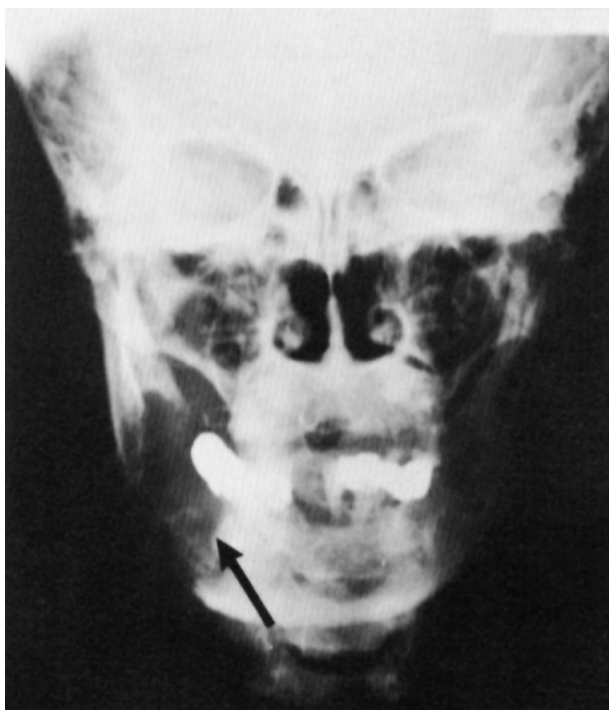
Radiographic appearance showing the tumor (arrow) in the right mandible. Wide destruction of bones is observed.
